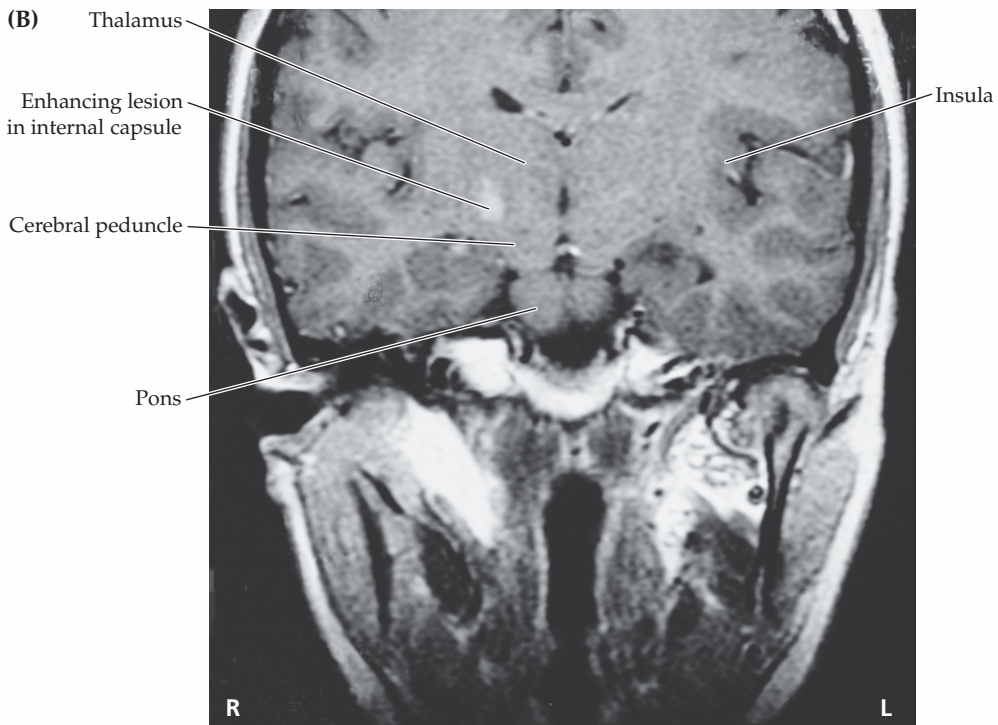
Lesion in Posterior Limb of Right Internal Capsule MRI of the brain. (A) Axial (horizontal) proton density-weighted section. (B) Coronal T1-weighted
